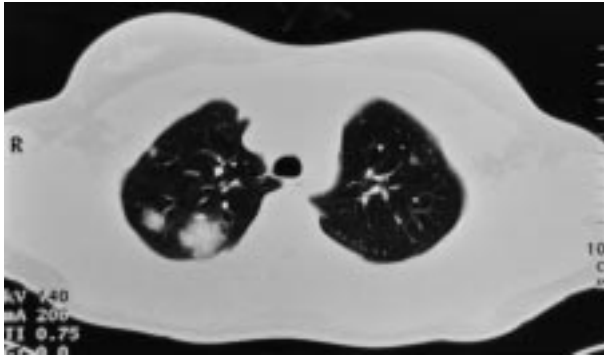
Computed tomography scan of the thorax, above the aortic arch, showing nodules.
